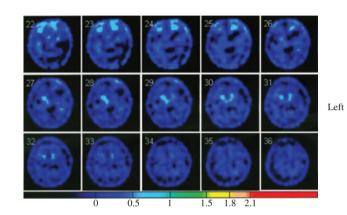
The dopamine transporter brain image (SPECT; in radiological orientation) was performed 4 h after 25mCi of Tc-99m TRODAT. The colour bar reflects the availability of dopamine transporter, which indexes the density of dopamine neuron, with a score above 1.8 rated as normal and the score below 1 rated as abnormal. There was severe decreased uptake of radioactivity involving the bilateral striatum, more prominent on the left.
